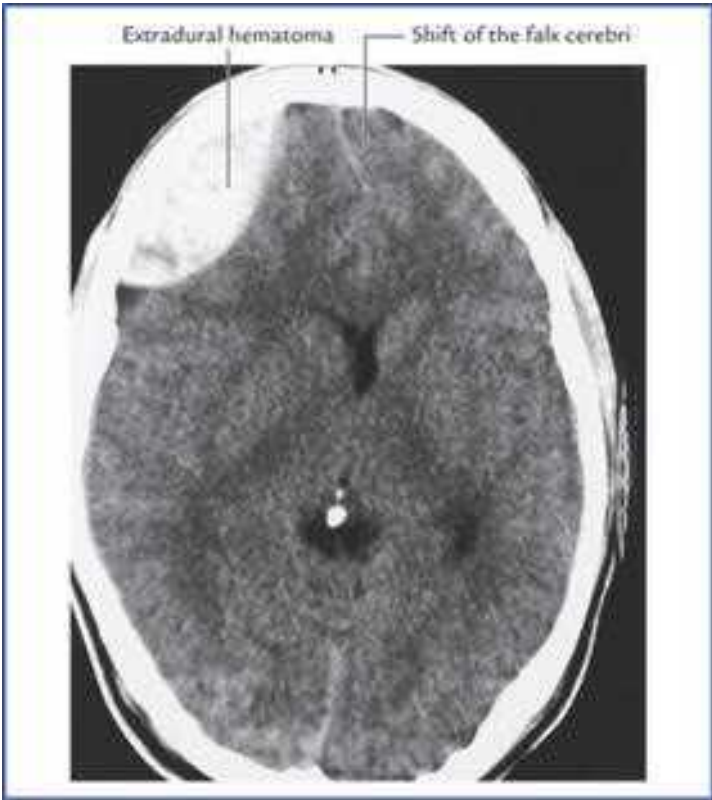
CT scan of brain showing extradural haemorrhage/ haematoma. Source: Drake, Richard L, Vogl, Mitchell, Adam WM. *Grays Anatomy for Students*. Philadelphia: Elsevier, Inc., 2005
